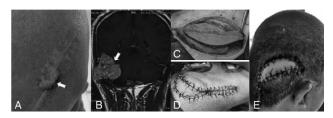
(A) The scar of first incision. (B) MRI showed intracranial tumor invaded subcutaneously. (C) Latissimus dorsi flap was used as donor flap. (D) The latissimus dorsi flap transplantation performed for filling subcutaneous tissue defect. (E) One-year follow-up showed healed incisions without any complications.
